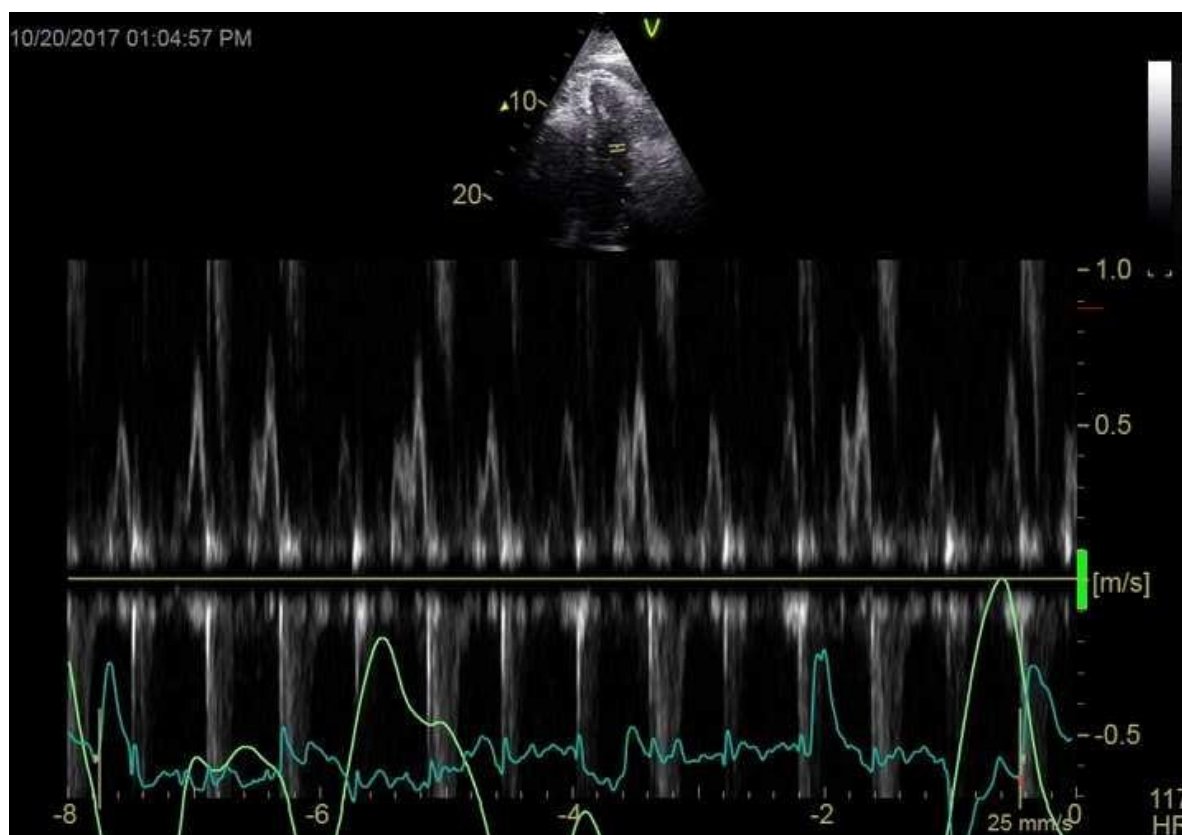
Echo with Doppler evaluation.
